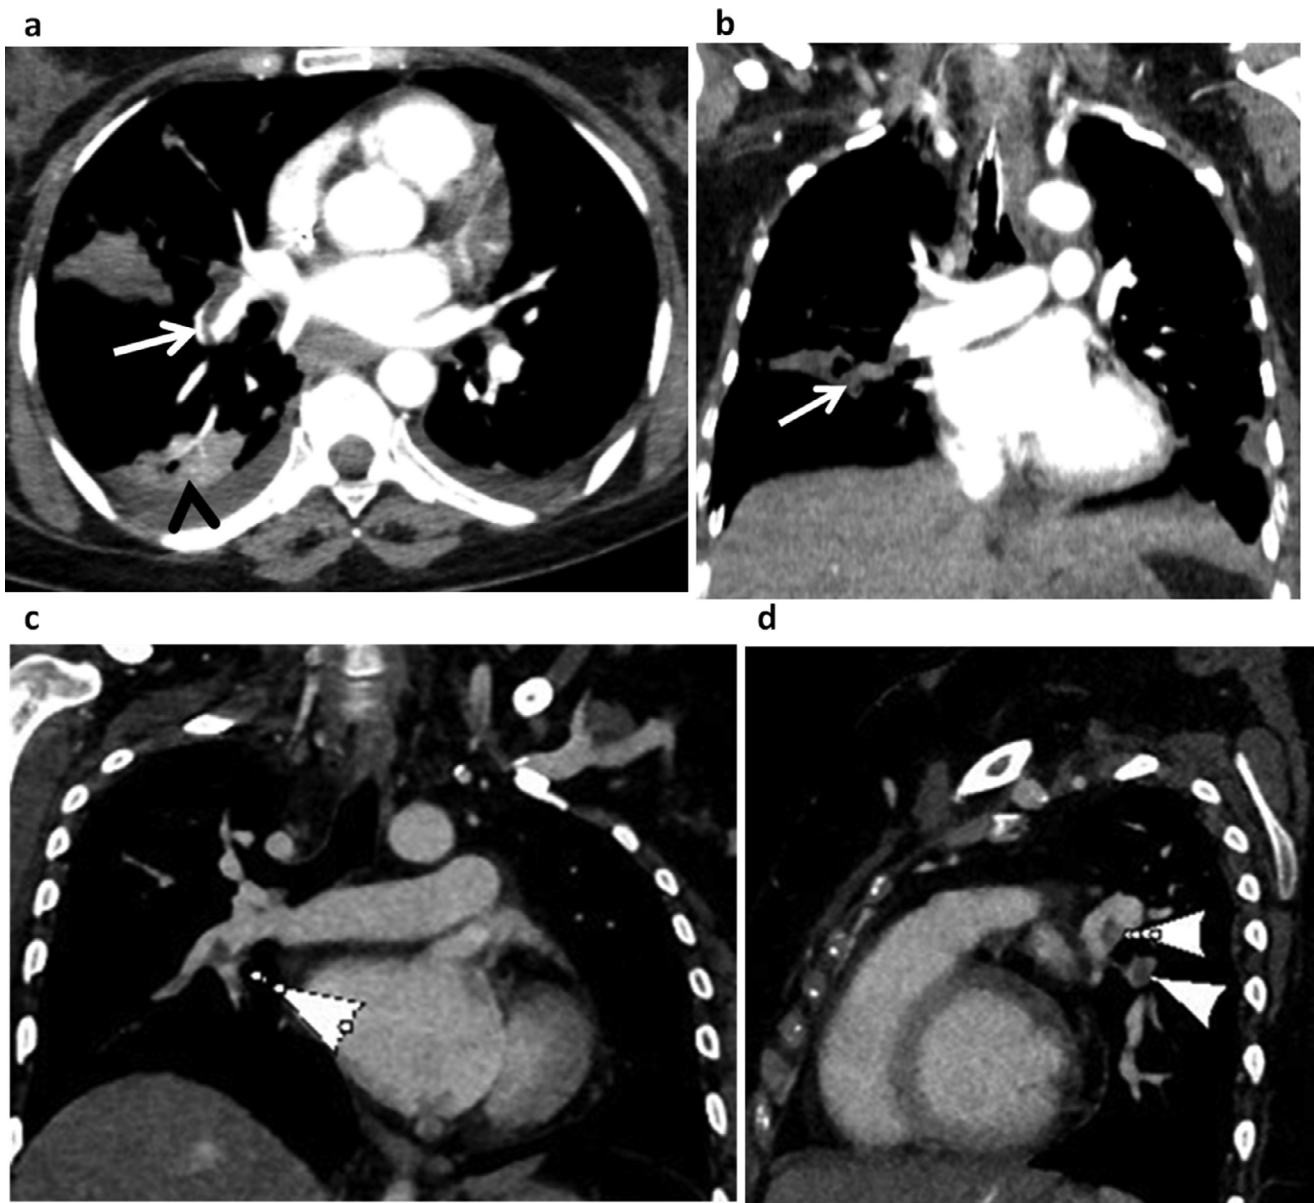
Pulmonary embolism. (A,B) Axial (A) and coronal reformatted (B) CT Pulmonary angiography (CTPA) images reveal a hypodense filling defect in the right interlobar pulmonary artery (arrow A,B). Bilateral mild pleural effusion and right basal atelectasis (arrowhead A) also noted. (C,D) Coronal (C) and Sagittal (D) reformatted CTPA images in a different patient shows filling defects in the right interlobar pulmonary artery and its segmental branches (arrowheads).
